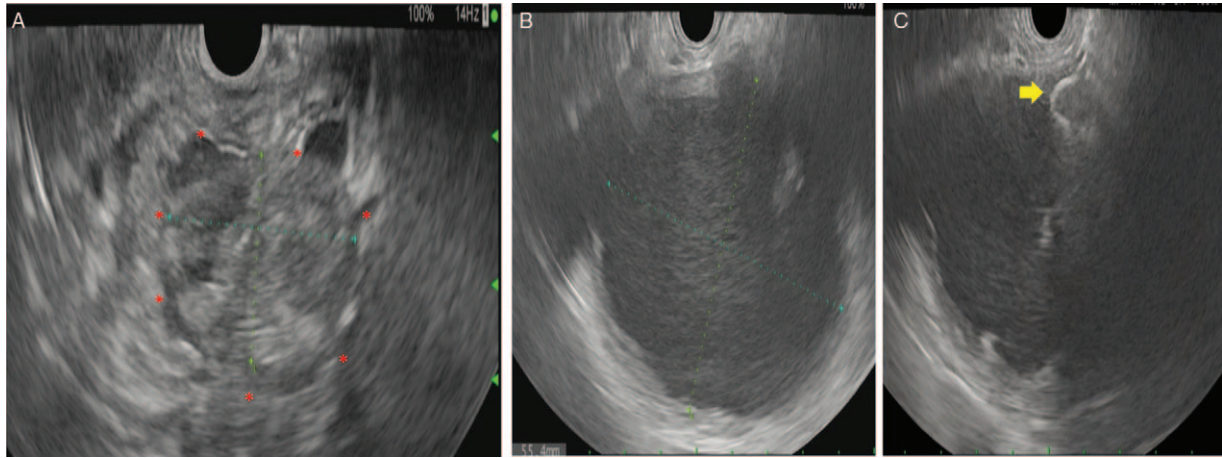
Endoscopic ultrasonography. (A) EUS image of 3-year-old child with walled-off pancreatic necrosis (i outlined by asterisks). (B) EUS image of a 14-year-old child with pancreatic pseudocyst. (C) EUS image of the same 14-year-old child with pancreatic pseudocyst with placement of a luminal apposing metal stent (arrow). EUS = endoscopic ultrasonography.
